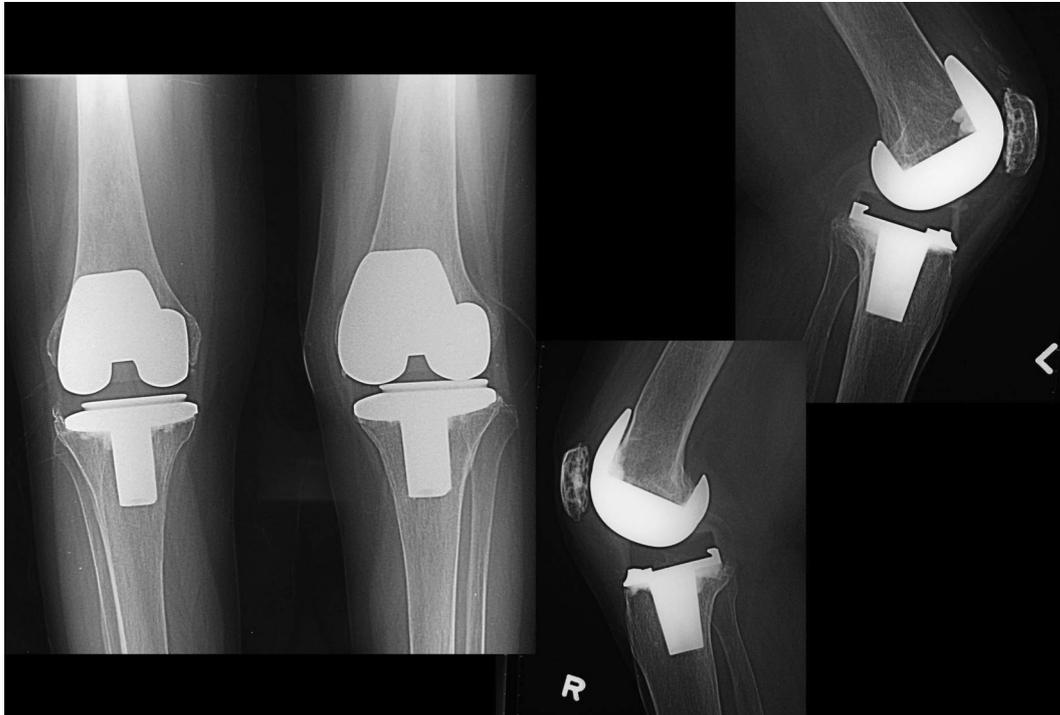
X-rays of the knees 2 years after total knee arthroplasty.
